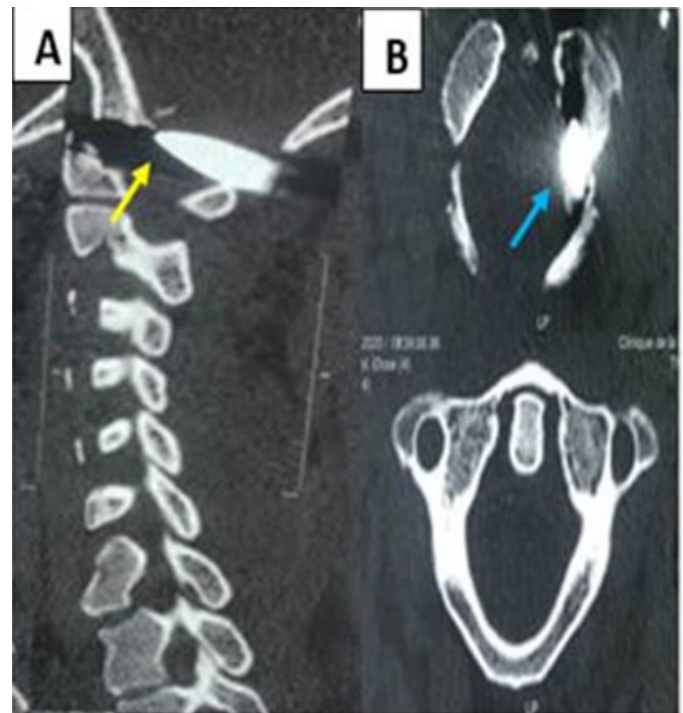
Cervical CT scan, (A) axial slice, (B) sagittal reconstruction: showing the presence of a projectile at the level of the left occipito-atloid joint with fracture of the internal cortex of the ipsilateral condyle (yellow and blue arrow).
